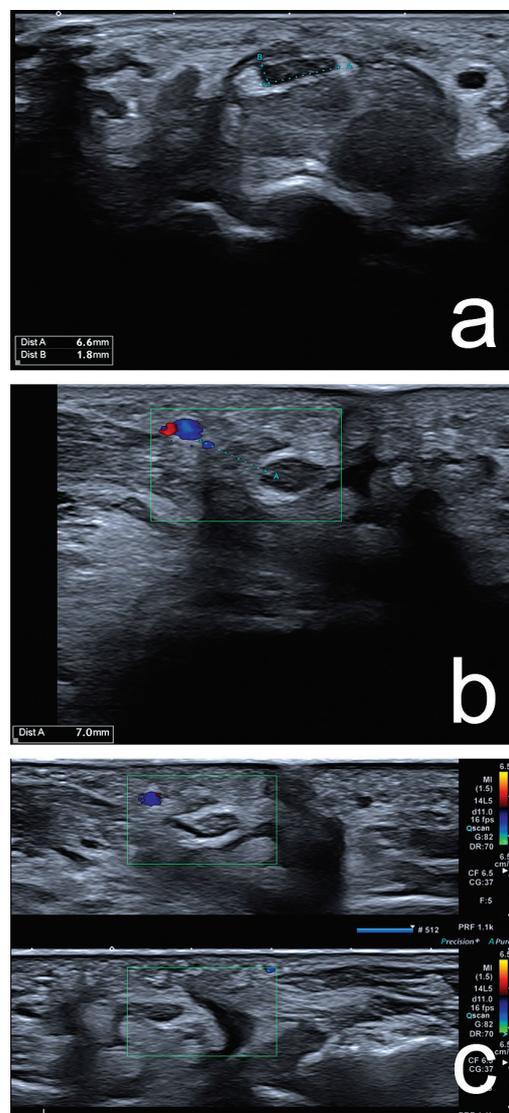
Ultrasonography presented a thickened MN (a) and clearly visualized the PMA (b); color doppler confirmed robust patency and flow within the PMA on the left side and its absence of the contralateral left hand (c)
